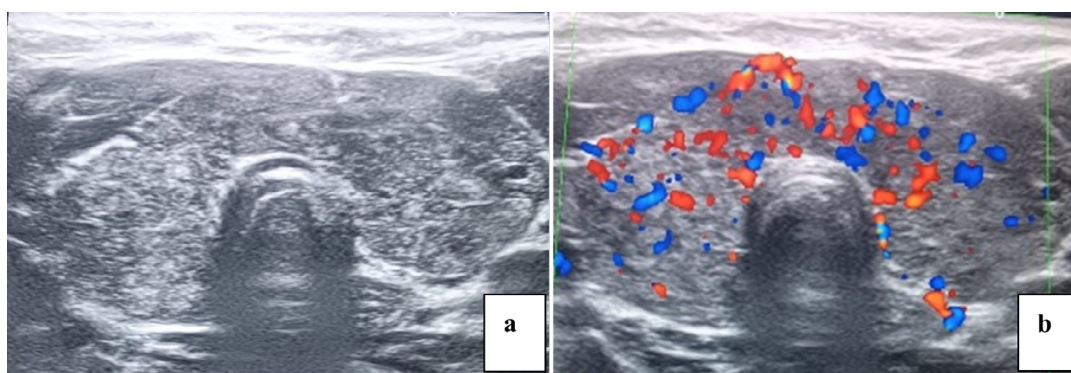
In the Same Patient Diagnosed with HT, Thyroid Ultrasound (a) in B-mode Reveals Extensive Enlargement of the Thyroid Gland with Heterogeneous Echotexture, and (b) Demonstrates Diffuse Enhanced Vascularity on Colour Doppler.
